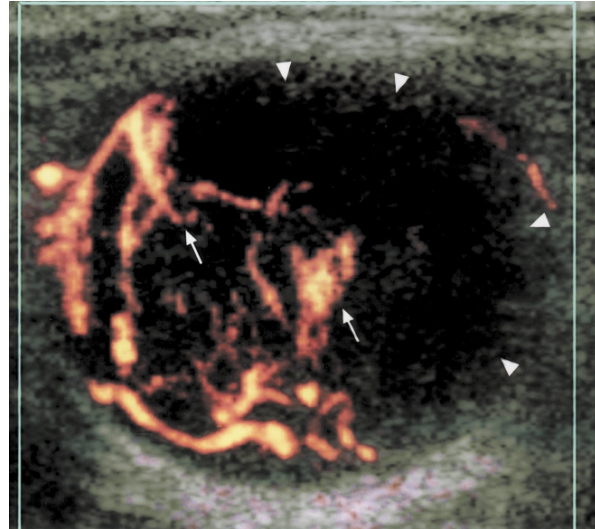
Power Doppler sonogram of a tuberculous node with displaced vascularity (arrows). Note the hypoechoic area within the lymph node (arrowheads) indicating intranodal cystic necrosis which displaces the vessels.
